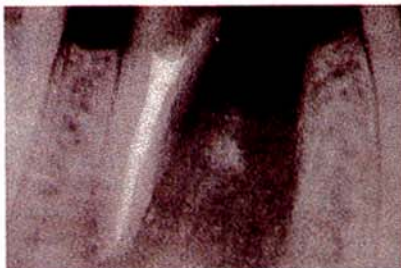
A periapical radiograph should be taken immediately after the tooth resection prior to suturing. This allows the dentist to modify the preparation, e.g. if the furcation has not been completely eradicated.
